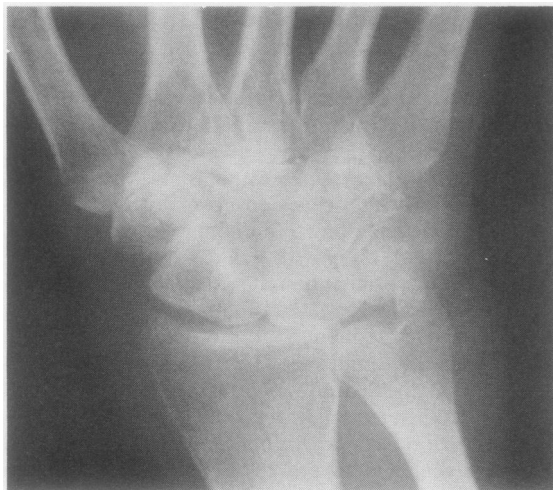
Radiograph of the right wrist revealing classical changes of adult Still's disease including intercarpal and carpal-metacarpal narrowing and fusion.
